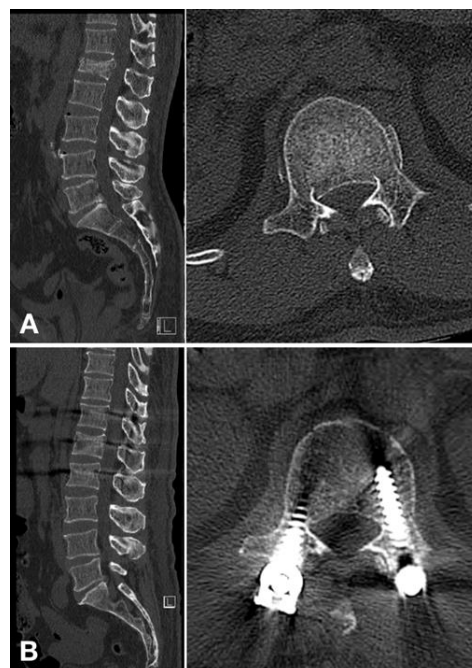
A, A 56-year-old male patient showed a complete burst fracture at L1. B, Postoperative CT images after postural reduction and posterior percutaneous screw fixation.
